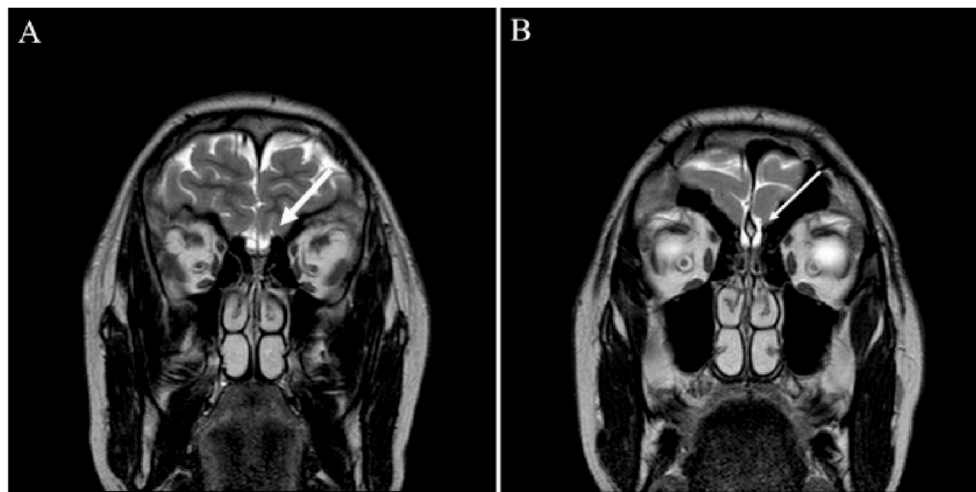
Coronal magnetic resonance image showing presence of both olfactory bulbs (A) and olfactory sulci (B).
